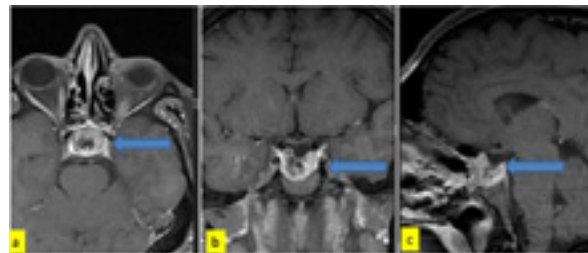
Postoperative MRI patient number (1) a: T1 axial, b: T1 coronal, c: sagittal T1 contrast enhanced MRI of pituitary gland showing heterogeneous enhancement of remnant
